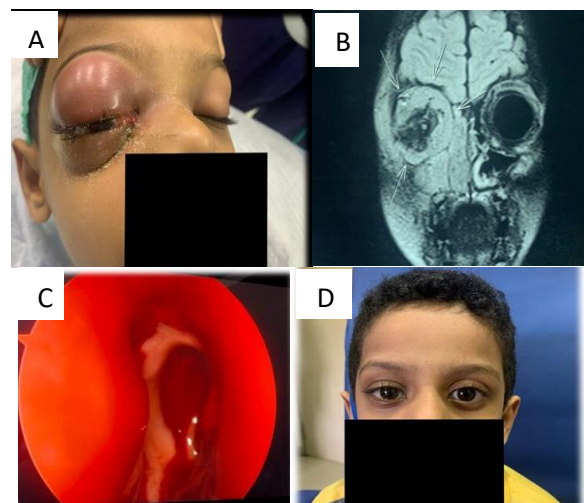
(A) Clinical picture; (B) MRI brain- abscess within intraconal muscle (R) eye (C) abscess in the intraconal muscles & (D) follow up-4 weeks drained endoscopically.
